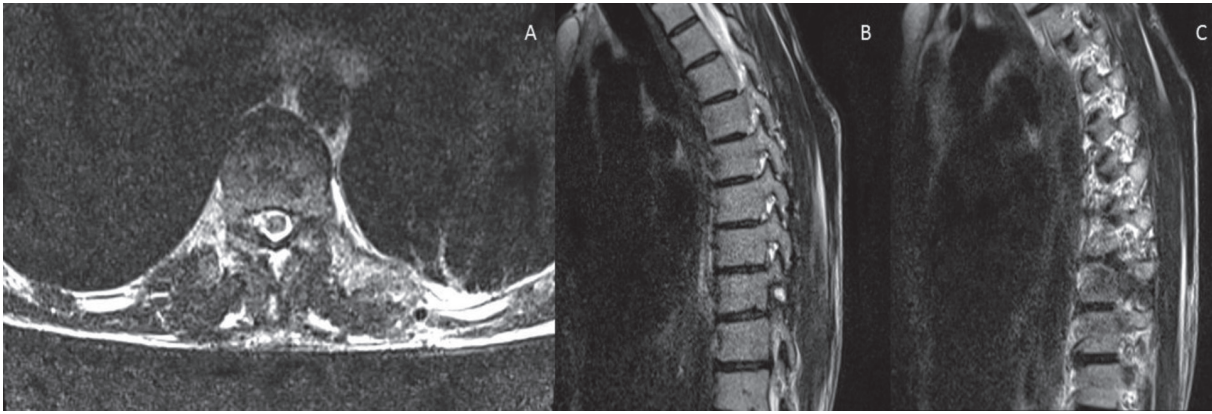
Postoperative MRI of the thoracic vertebra. Figures 5A, 5B and 5C demonstrate that no obvious residual or recurrent disease exists after complete excision of the tumor.
